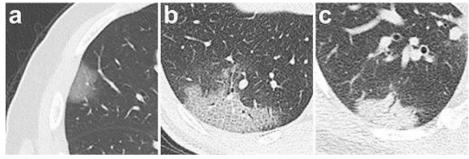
Chest CT findings of COVID-19 pneumonia on transaxial images.⁷ (a) GGO (b) Crazy-paving pattern (GGO with superimposed inter- and intralobular septal thickening). (c) Consolidation.
